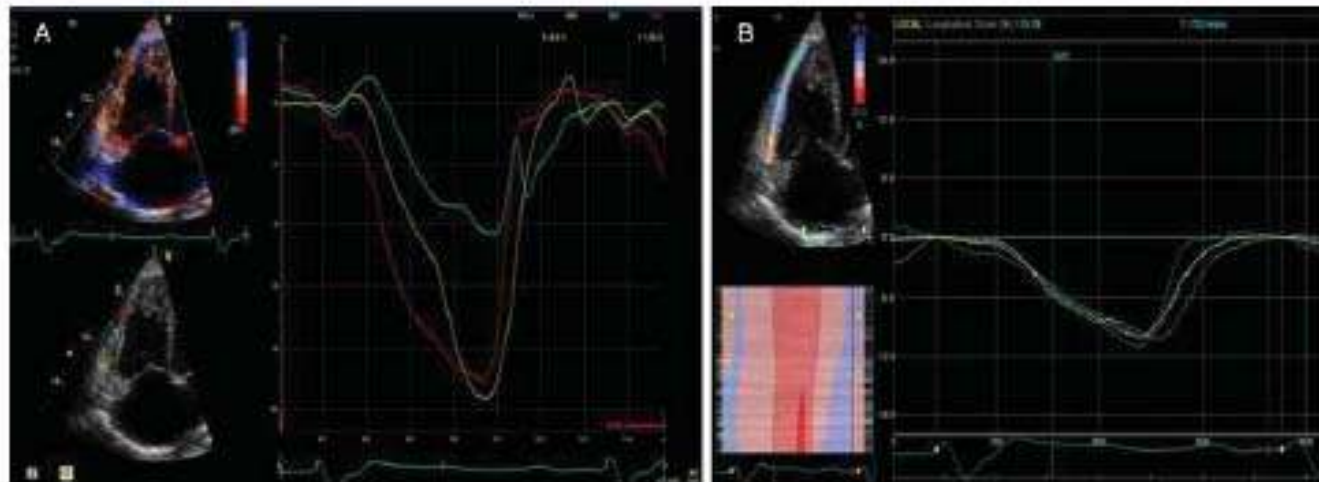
Strain rate imaging of the right ventricular free wall in a pulmonary hypertension patient using tissue Doppler techniques (A) and speckle-tracking techniques (B).
